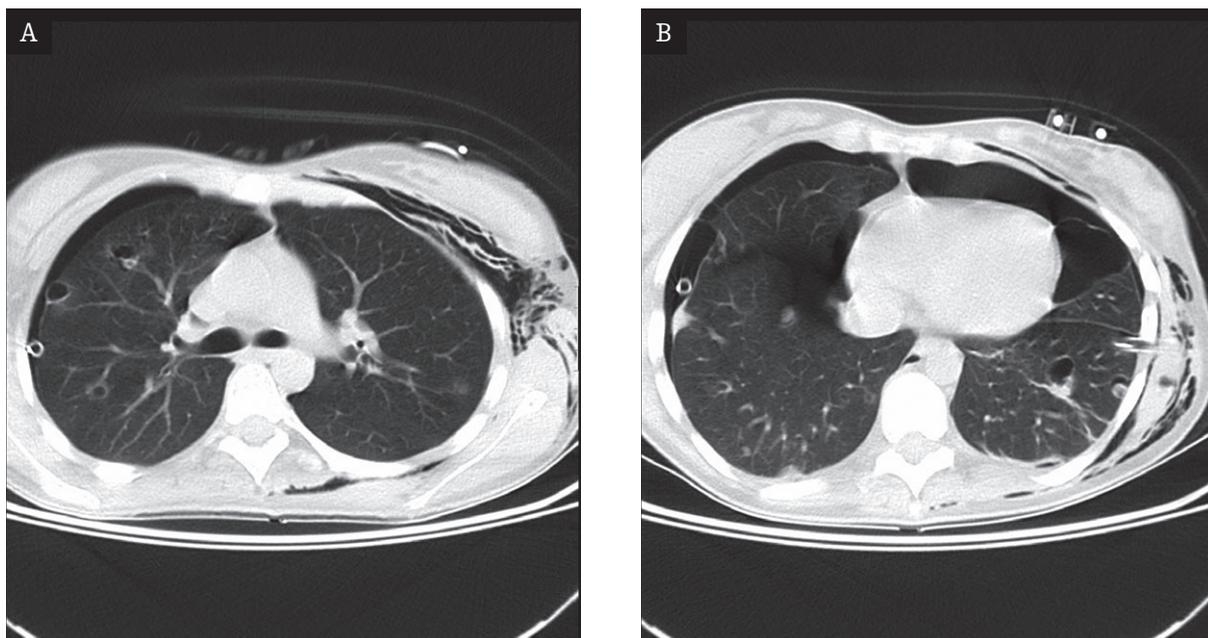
A, B. CT, image of the lungs after two months of chemotherapy.
